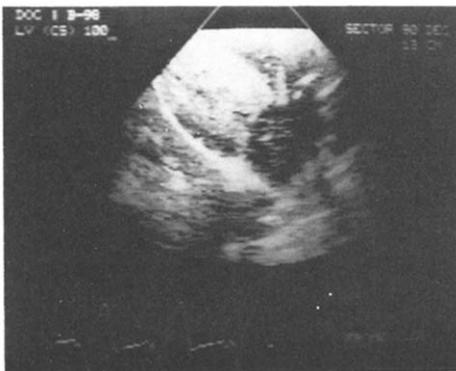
Two-dimensional echocardiographic image of a left ventricular (LV) contrast injection during left ventricular basal pacing. Some contrast appears in the left atrium (LA), although to a much lesser degree than with right ventricular apical pacing. CS = coronary sinus.
